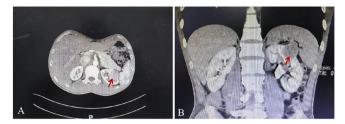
Results of the abdominal CT scan. (A) A well-circumscribed and slightly heterogeneous enhancing mass of the left kidney in the arterial phase (red arrow). (B) A 3D reconstruction showed that the tumor was a 2.6x3.3x2.8 cm mass with a solid component and located in the left renal (red arrow). The right kidney was normal.
